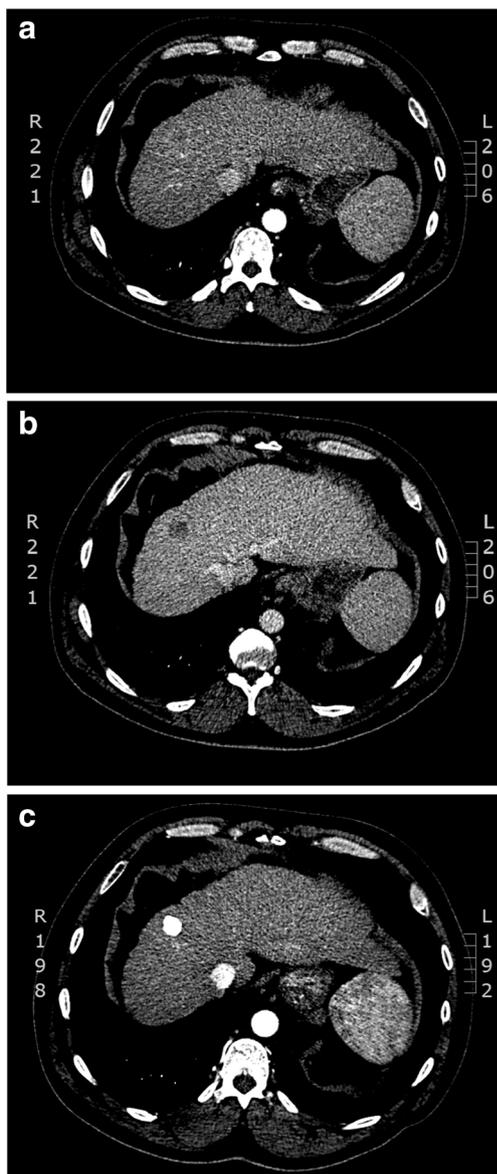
Triphasic computed tomography (CT) scan of hepatocellular carcinoma (HCC). a CT Scan with single hypervascular lesion in segment 8, with b subsequent venous washout. c Imaging immediately post-TACE with good uptake of lipiodol
